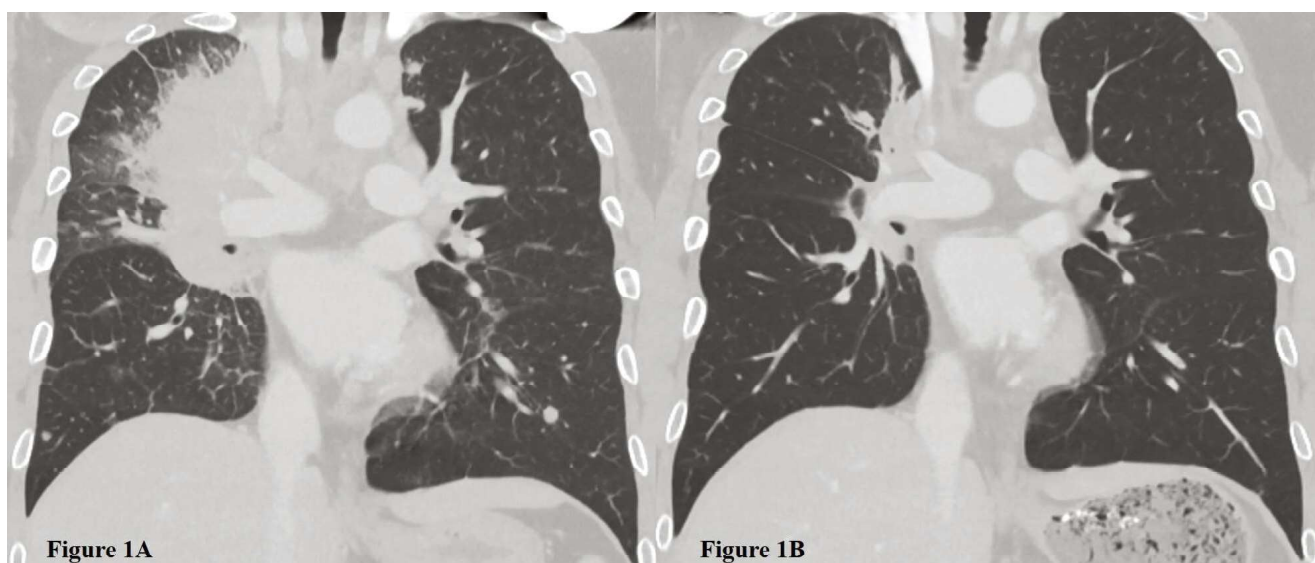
A: Coronal view of the patient's chest CT at the initial diagnosis of lung cancer. B: Coronal view of the patient's chest CT 6 months after diagnosis after treatment with selpercatinib and local radiotherapy. The primary tumor and lung metastasis are reduced.
